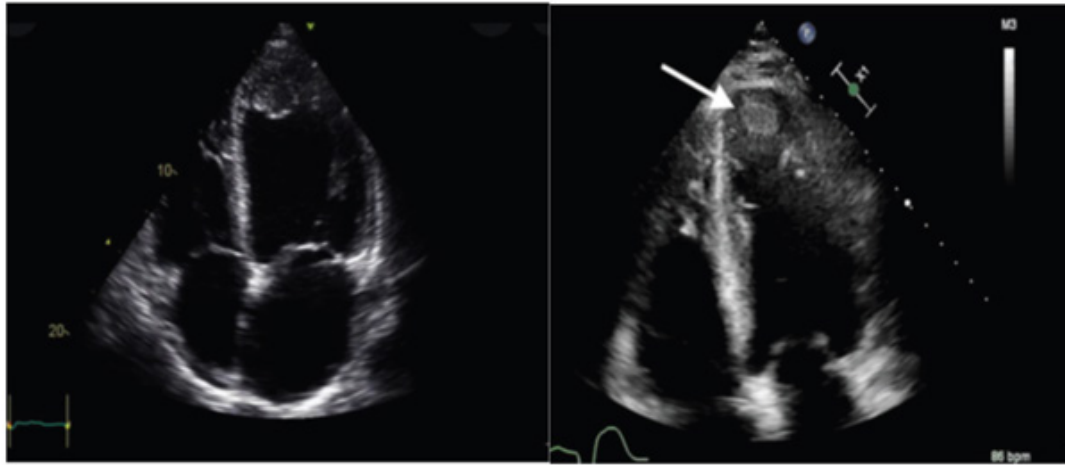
Transthoracic 2D echocardiography in apical 4-cavity section: there is evidence of apical thrombosis 16/16 mm in size.
